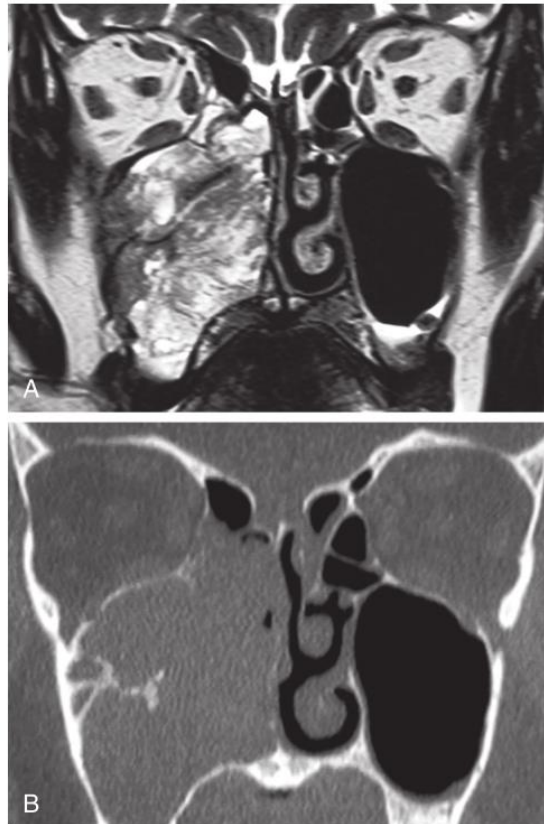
Inverted papilloma on a magnetic resonance image (MRI) and a computed tomography (CT) scan, both in the coronal plane. The maxillary sinus is completely occupied by an expansile lesion that destroyed the medial wall and invaded the right nasal fossa. A, The T2-weighted spin-echo MRI demonstrates the cerebriform-columnar pattern of the lesion and permits visualization of the bony spur along the lateral maxillary sinus wall, where the lesion originates. B, The CT scan does not provide a good characterization of soft tissue density opacification but gives a superior view of the sclerotic bony spur.
